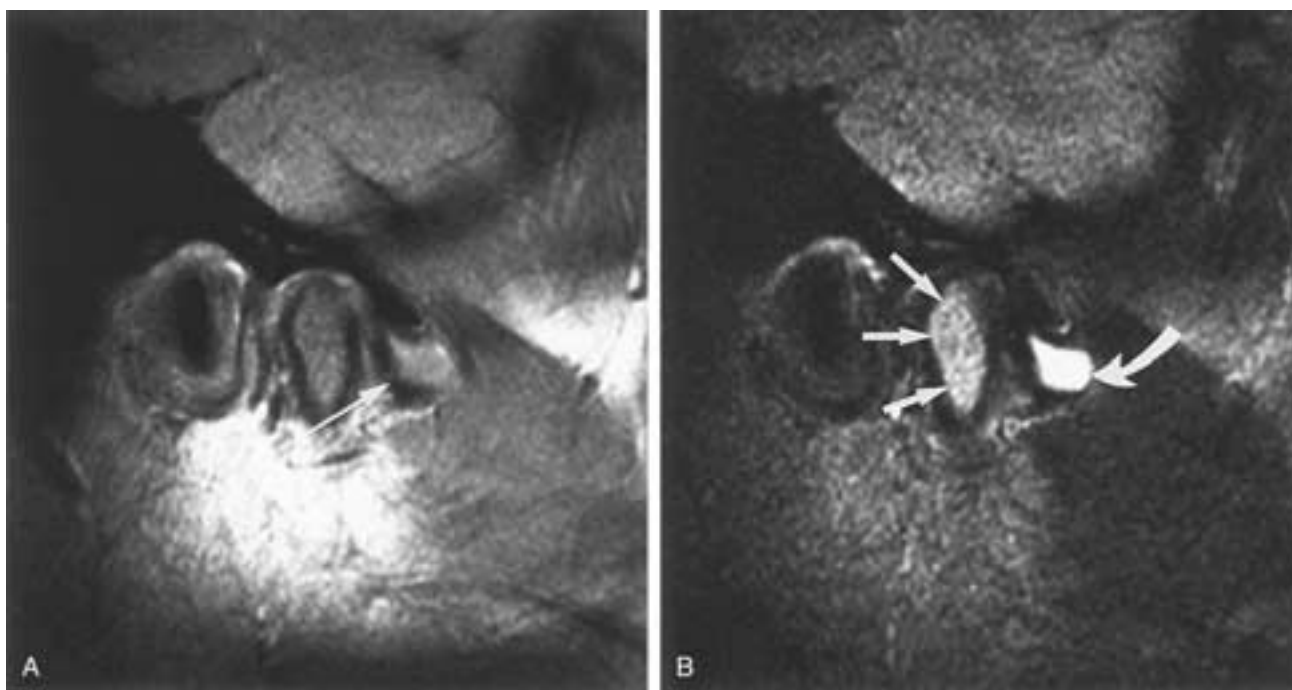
Bone marrow edema. A, Proton density sagittal MR image shows anterior displacement of the disk (*arrow*). B, T2-weighted image shows increased signal in the bone marrow of the condyle (*arrows*). There is also a large effusion (*curved arrow*) in the upper joint space. The increased signal in the bone marrow indicates bone marrow edema.
